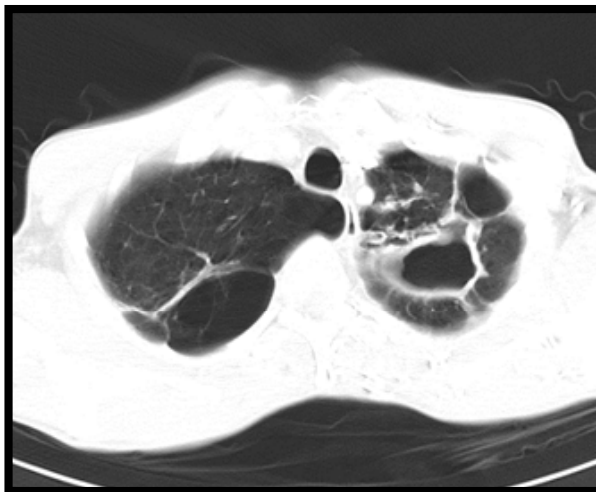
Computed Tomography scan of the thorax of the same patient as in figure 1 showing widespread cavitation in the left upper lobe bullous changes in the right lung as well around the cavity. (source: Hospital Drachten, the Netherlands).
